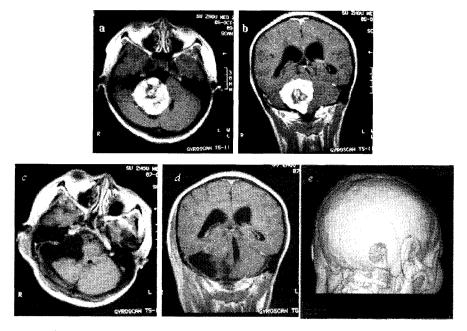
The preoperative and postoperative images of one patient with right acoustic neurinoma resected via a retromastoid keyhole approach. a, b Preoperative MRI; c, d MRI on the fist postoperative day; e The skull demonstrated by the reconstructed 3D-CT obtained one week postoperatively
